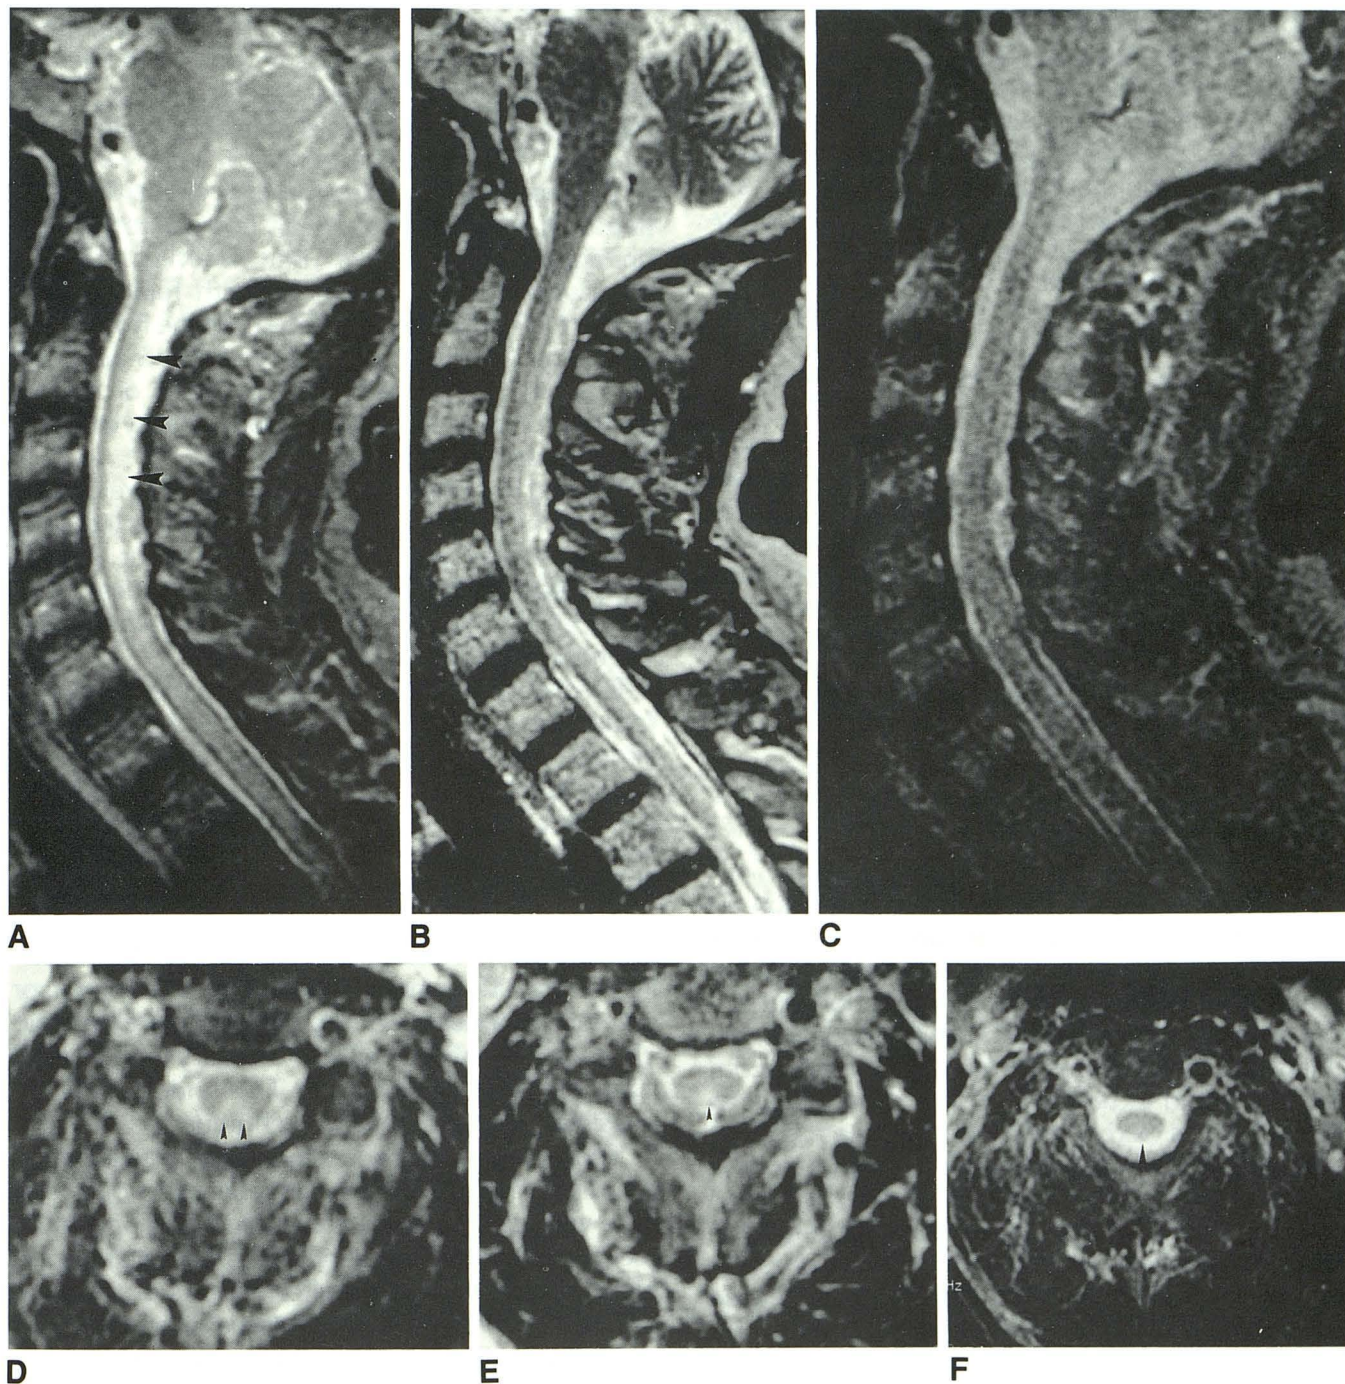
A* and *D*, Midline sagittal (1875/90/1 [TR/TE/excitations]) and axial (2000/90) T2-weighted spin-echo images of the cervical spinal cord demonstrate abnormal increased signal intensity in the posterior columns (*arrowheads*).
